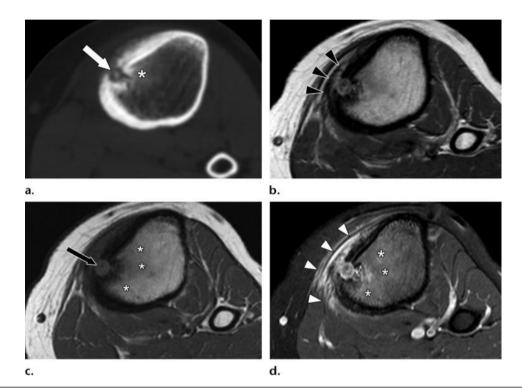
Tibial Intracortical osteoid osteoma - (a) CT shows nidus (arrow) with central calcification and adjacent sclerosis (*) (b) Axial T2W MR reveals heterointense nidus. (c, d) Axial plain and Post contrast T1W MR reveals low-signal intense nidus with strong enhancement, with adjacent edema (*) (4).
